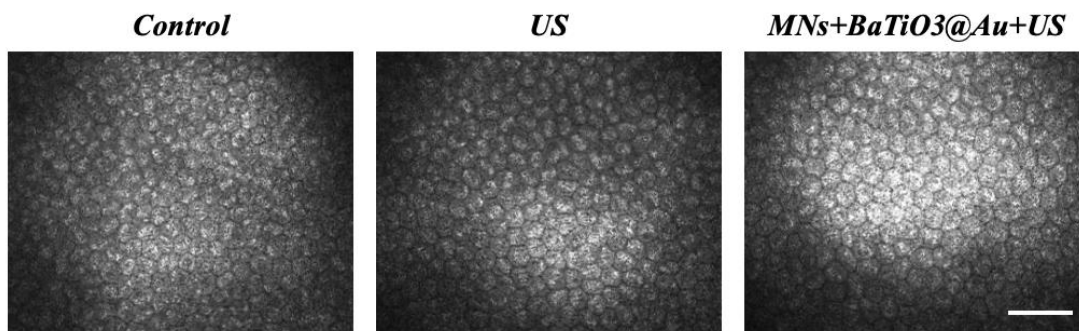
Representative images of the central corneal endothelium acquired immediately after different treatment, including untreated control, ultrasound alone, and MNs+BaTiO₃@Au+US. Scale bar: 50 μm.
